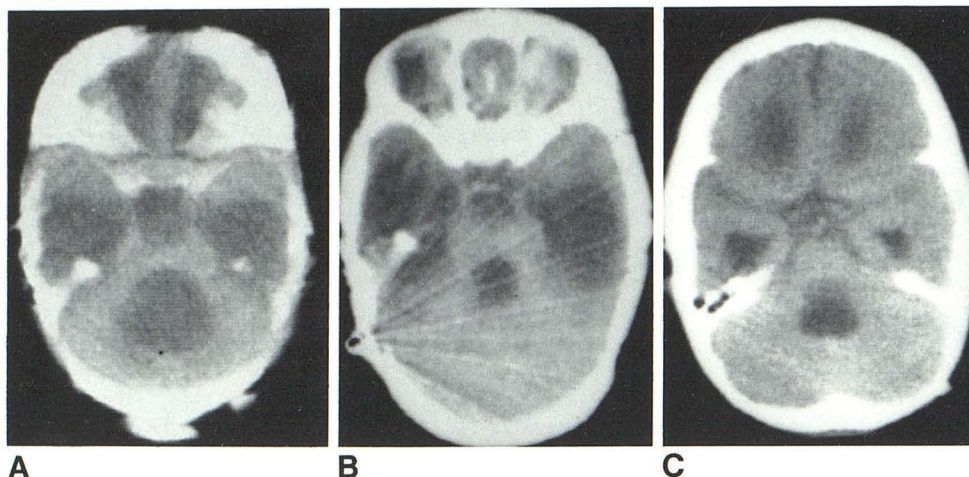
Isolated, ballooned fourth ventricle. A, Initial CT scan. Ballooned fourth ventricle. Marked dilatation of temporal horns and anterior inferior third ventricle. B, 2 months later. Significant diminution of fourth ventricle, indicating patent aqueduct of Sylvius. C, 9 months later. Progressive enlargement of fourth ventricle consequent to postshunting aqueductal stenosis.
